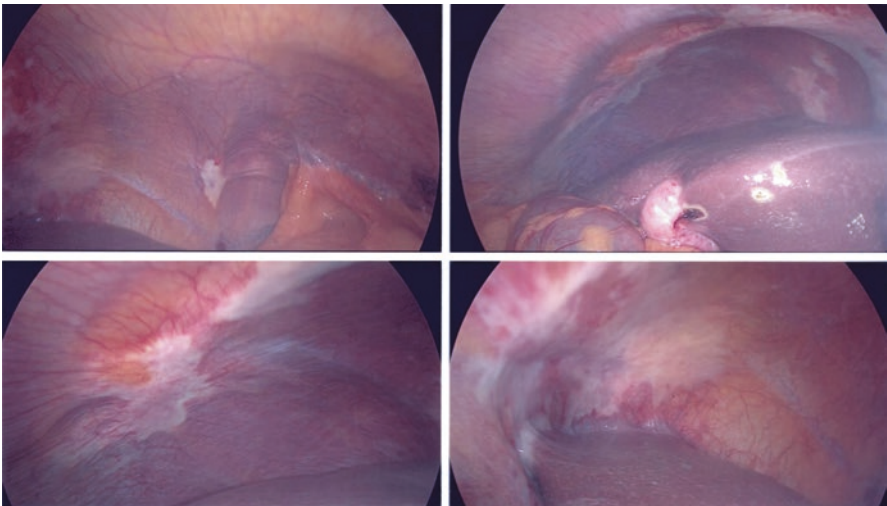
Intraoperative photographs during staging laparoscopy for intrahepatic cholangiocarcinoma. Biopsies of white areas on peritoneal were positive for cholangiocarcinoma peritoneal carcinomatosis not visualized on preoperatively CT scan
